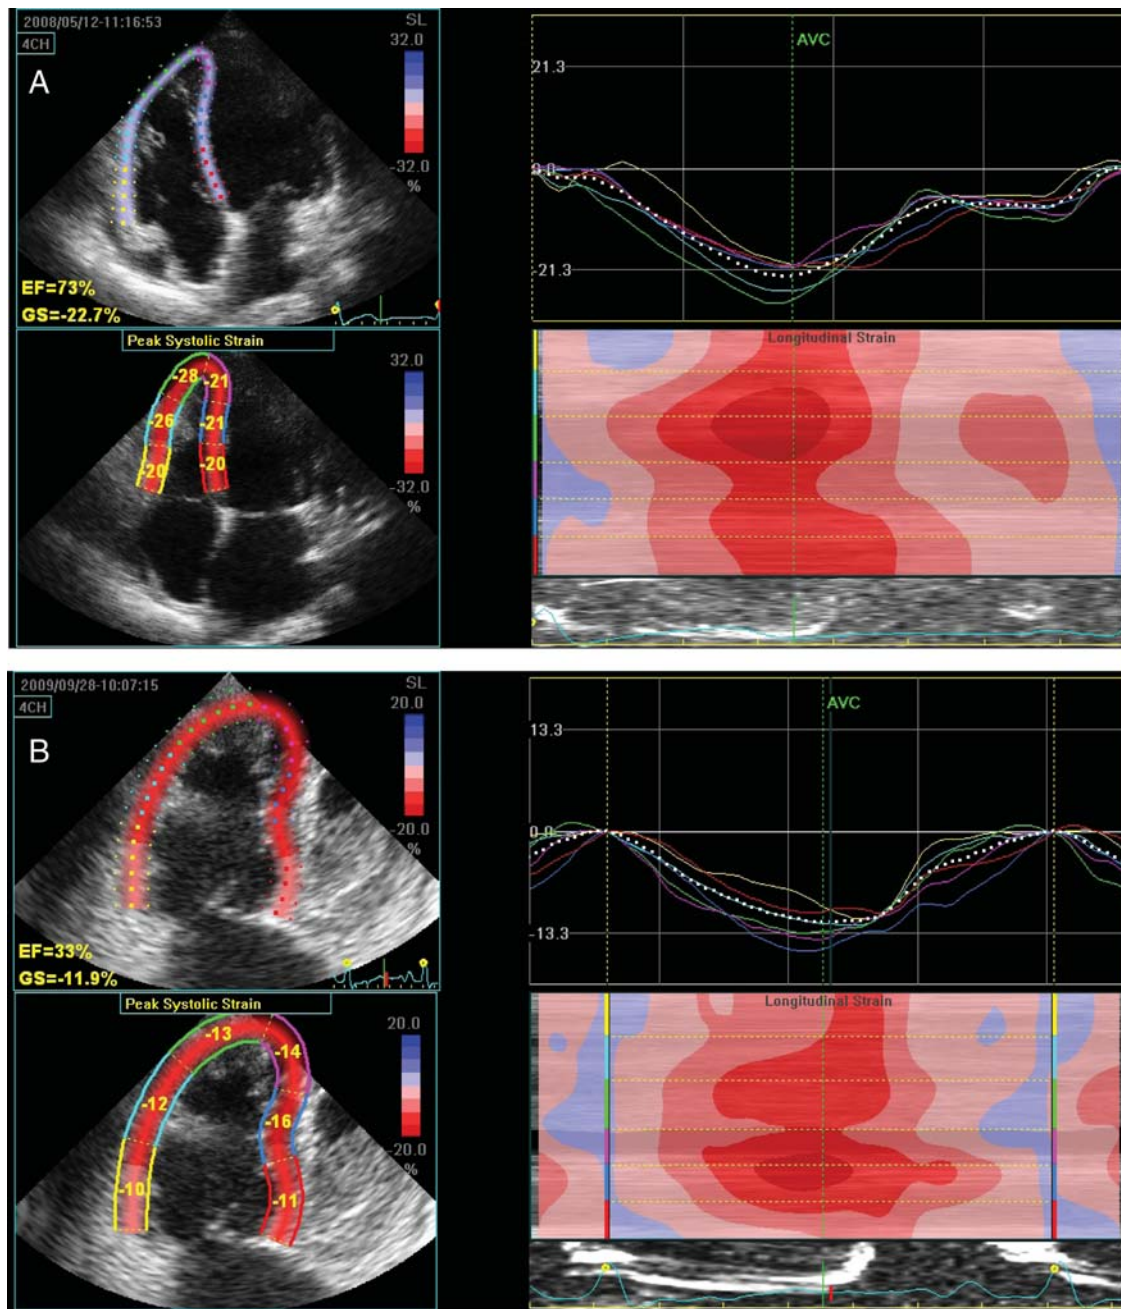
Longitudinal strain of the right ventricle assessed using STE from an apical four-chamber view in a normal subject (A) and in a patient with altered RV function (B). GS, Global strain.
